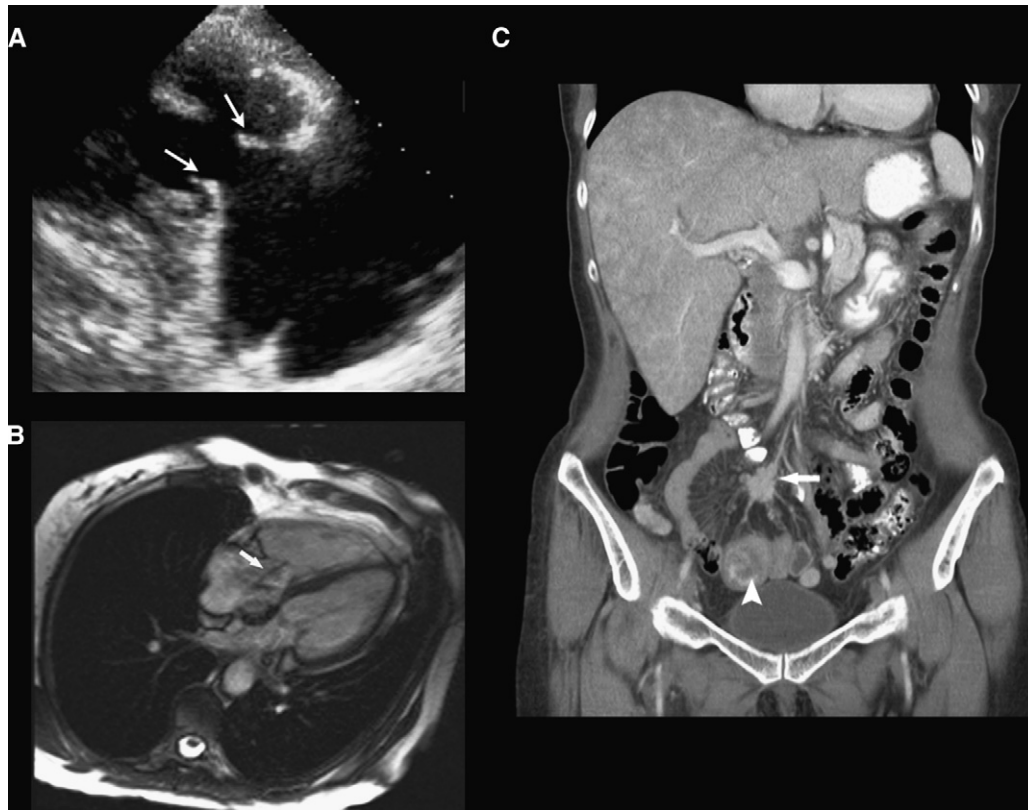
(A) Transthoracic echocardiographic right ventricular inflow view, demonstrating immobile tricuspid valve leaflets (arrows) consistent with carcinoid heart disease. (B) Four-chamber view obtained with balanced, steady-state, free precession magnetic resonance, demonstrating a linear signal void that resulted from tricuspid regurgitation (arrow) because of carcinoid heart disease. (C) Coronal contrast-enhanced computed tomography image, demonstrating a speculated nodal mass in the mesentery (arrow), which has metastasized from a more inferiorly located primary tumour in the small bowel (arrowhead).
